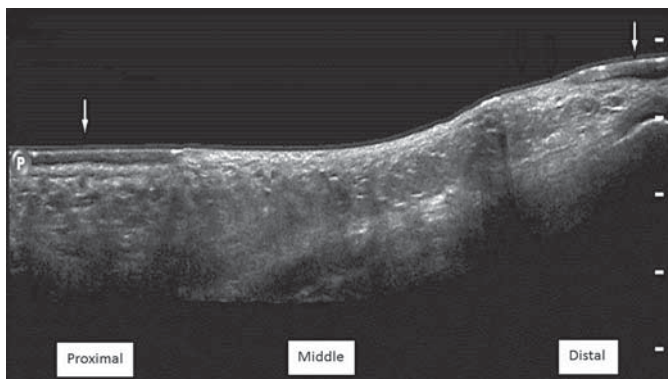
Panoramic ultrasound view of the whole plantar foot in a PC patient. The differences between the middle plantar and both proximal and distal plantar skin (arrows) are clearly demonstrated.
